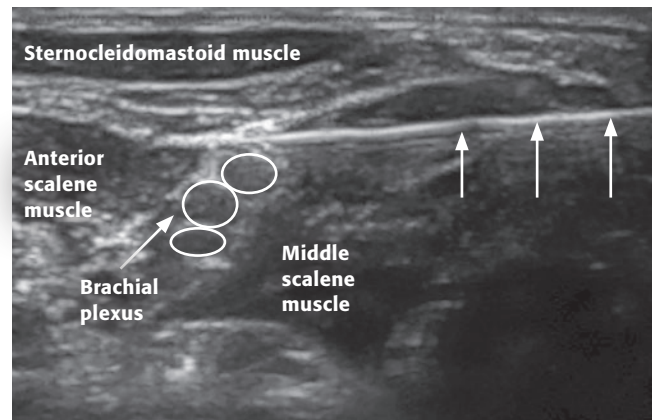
Ultrasound image of interscalene brachial plexus with needle in the in-plane orientation. Arrows point to the incoming needle.
